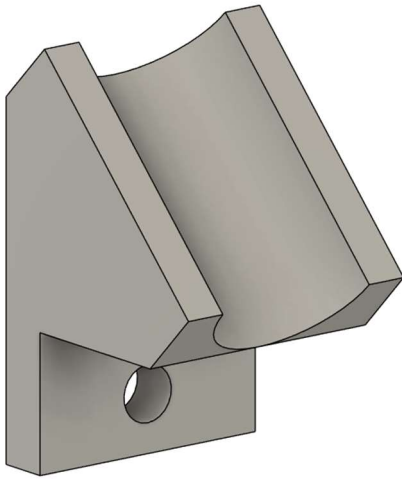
Transducer Bracket. 3D model in Fusion 360 for a bracket designed to support an ultrasound transducer in the angled trough. The hole is for the tubing to go through, ensuring the tubing is at the optimal focal depth.
